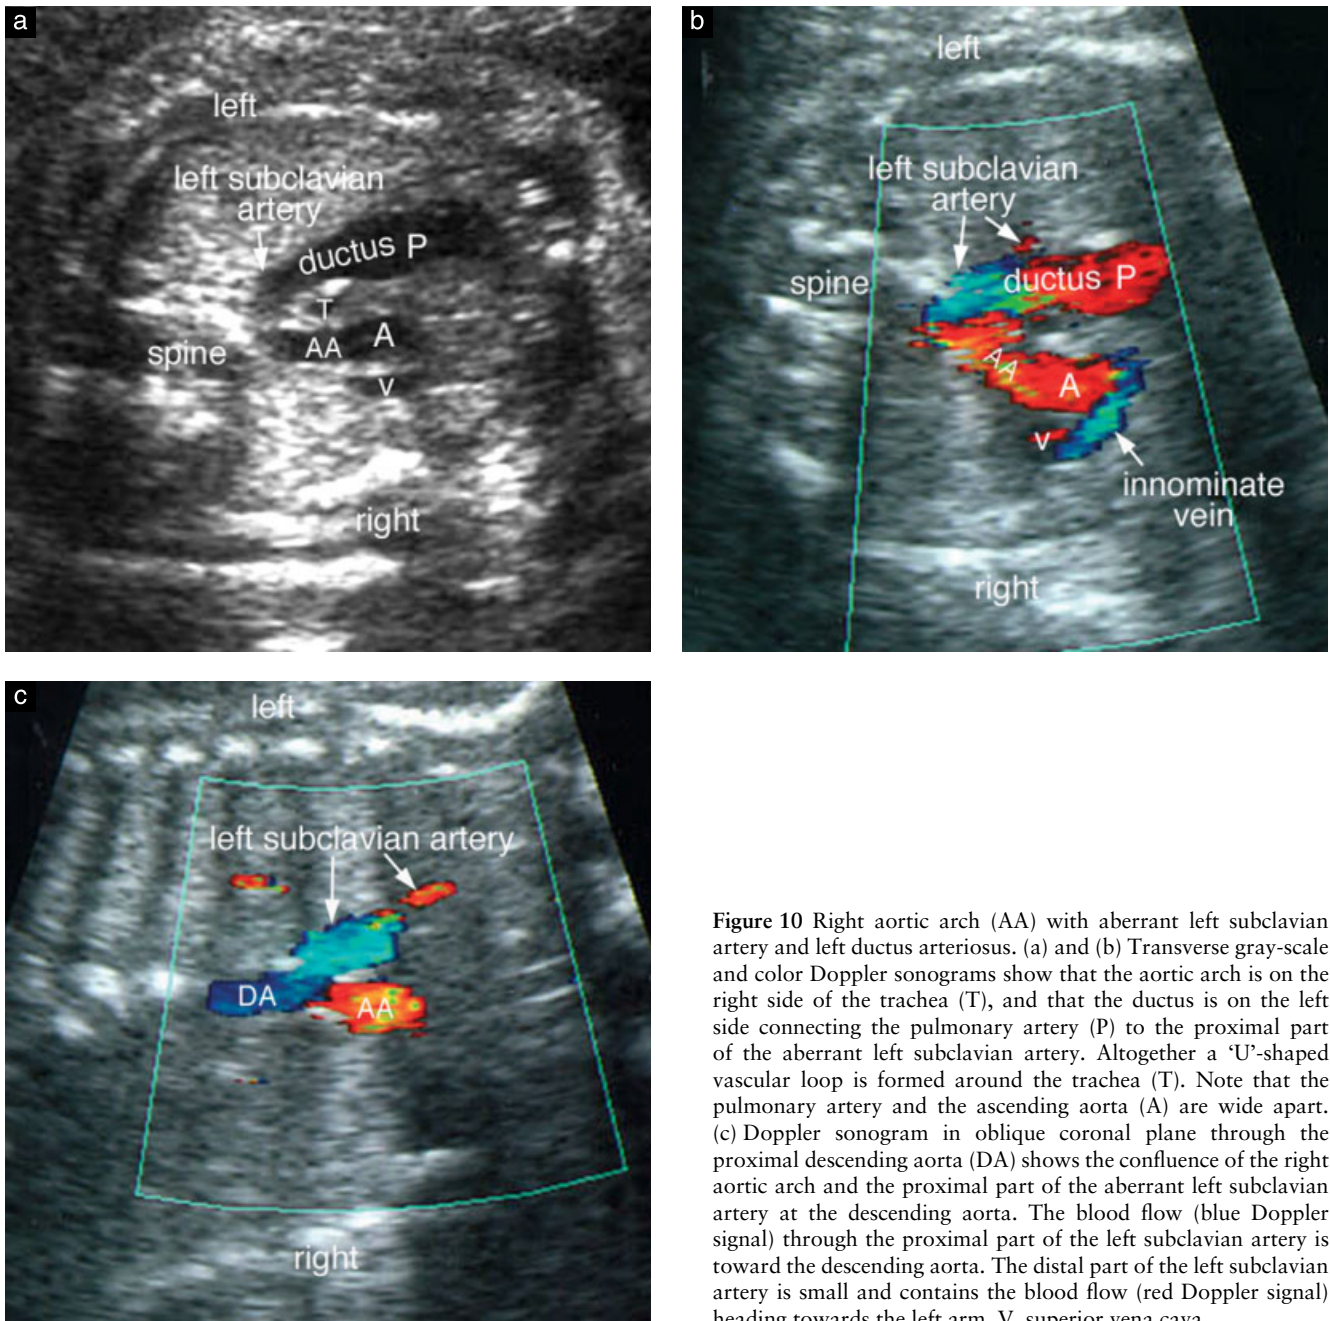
Right aortic arch (AA) with aberrant left subclavian artery and left ductus arteriosus. (a) and (b) Transverse gray-scale and color Doppler sonograms show that the aortic arch is on the right side of the trachea (T), and that the ductus is on the left side connecting the pulmonary artery (P) to the proximal part of the aberrant left subclavian artery. Altogether a 'U'-shaped vascular loop is formed around the trachea (T). Note that the pulmonary artery and the ascending aorta (A) are wide apart. (c) Doppler sonogram in oblique coronal plane through the proximal descending aorta (DA) shows the confluence of the right aortic arch and the proximal part of the aberrant left subclavian artery at the descending aorta. The blood flow (blue Doppler signal) through the proximal part of the left subclavian artery is toward the descending aorta. The distal part of the left subclavian artery is small and contains the blood flow (red Doppler signal) heading towards the left arm. V, superior vena cava.
